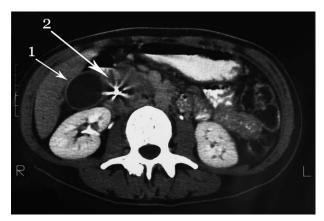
CT scan of the abdomen after the first cycle of systemic treatment showing the gallbladder (arrow 1) and regression of the tumor in the head of the pancreas (arrow 2). In the center of the tumor, an endoprosthesis is creating artifacts.
